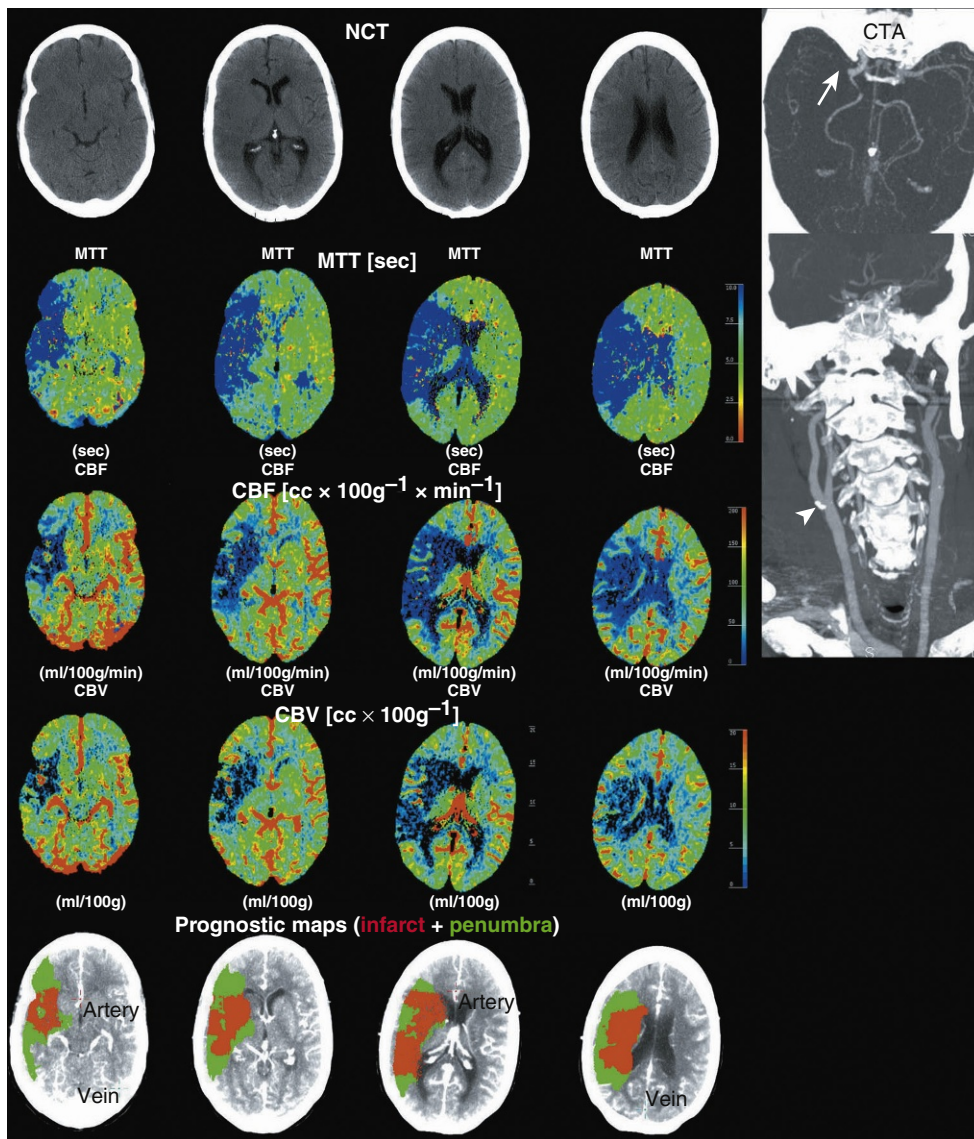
Modern computed tomography (CT) survey in a 57-year-old male patient admitted in our emergency room with a left hemisindrome, including an unenhanced CT (first row), a perfusionCT (PCT) (rows 2 through 5) and a CT-angiogram (CTA) (right column). The unenhanced CT ruled out a cerebral hemorrhage. From the PCT raw data, three parametric maps were extracted, relating to mean transit time (MTT, second row), cerebral blood flow (CBF, third row), and cerebral blood volume (CBV, fourth row), respectively. Application of the concept of cerebral vascular autoregulation led to a prognostic map (fifth row), describing the infarct in red and the penumbra in green; the latter being the target of acute reperfusion therapies. CTA identified an occlusion at the right M1-M2 junction (arrow) as the origin of the hemodynamic disturbance demonstrated by PCT. CTA also revealed a calcified atheromatous plaque at the right carotid bifurcation (arrowhead).
